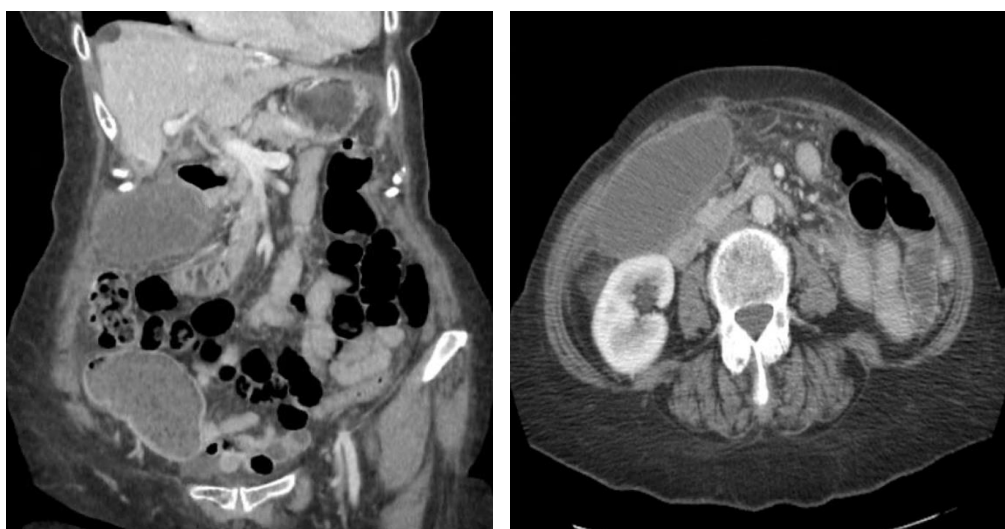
(CT Abdomen and Pelvis): Markedly distended gallbladder with wall thickening and pericholecystic inflammation. No definite gallstones. Mild to moderate intrahepatic biliary ductal dilation and enlargement of the common bile duct.
